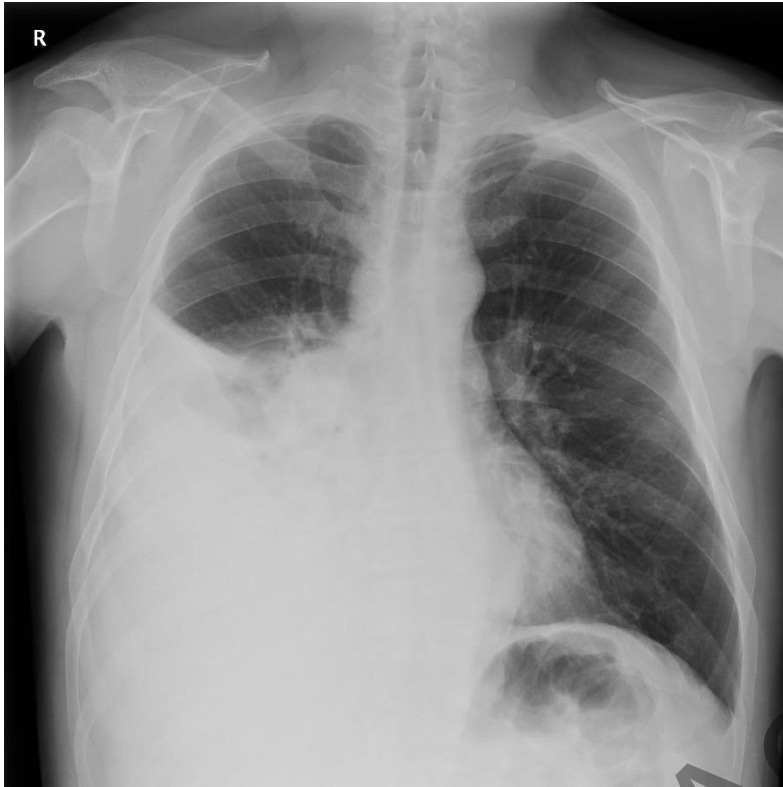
Initial chest radiograph
